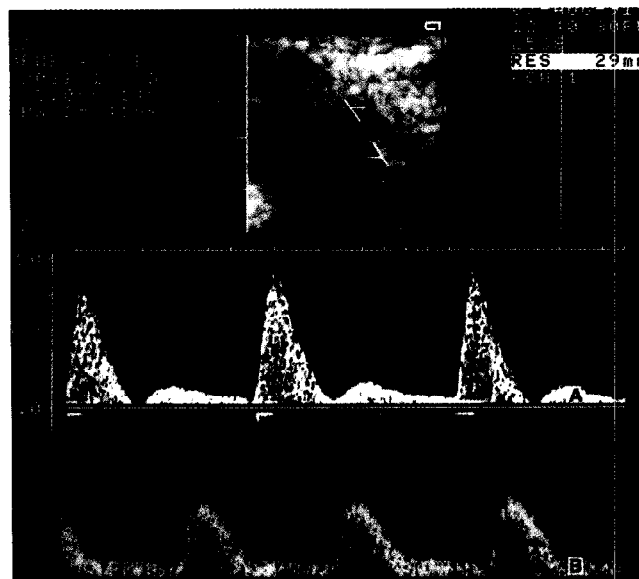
Abnormal uterine artery Doppler waveforms at 24 weeks. Failure of physiological change in the uterine circulation results in a waveform (A) that is similar to that of a non-pregnant woman (compare with Figure 1). In a small number of cases there is no apparent notch, but resistance remains elevated (B). If the resistance index was > 95th centile, a waveform was defined as abnormal, irrespective of the presence or absence of a notch
